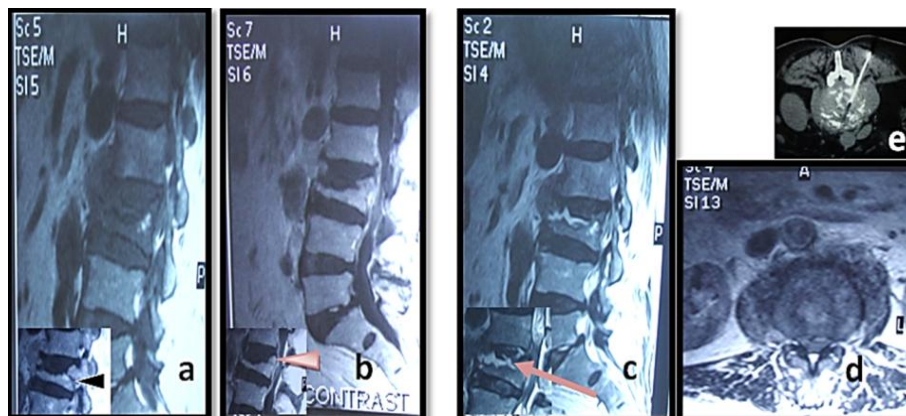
MRI of the lumbosacral spine in a 45-year-old man, a compression fracture , endplate disruption, L4 L3/L4 intervertebral disc involvement, and a para-vertebral collection(abscess- arrow head) beneath the anterior longitudinal ligament.(d)CGPCB: transpedicular approach, using 18 gauge spinal needle.Diagnosis : spondylidiscitis
